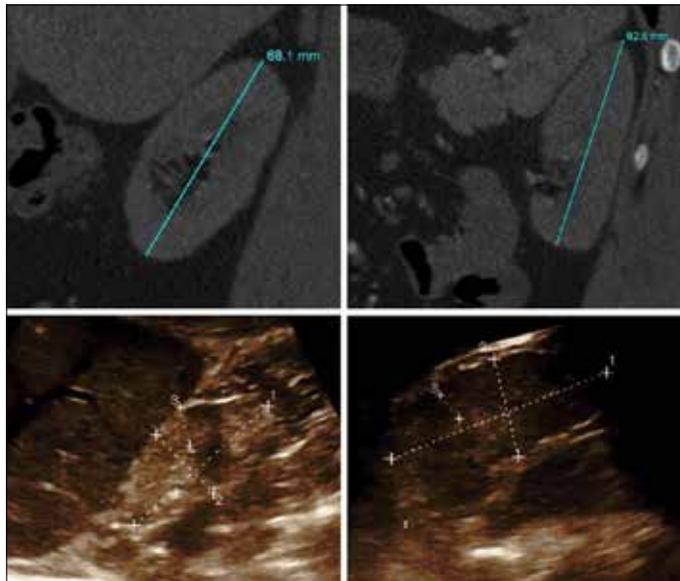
Abdominal ultrasonography and computed tomography views of bilateral renal hypoplasia
